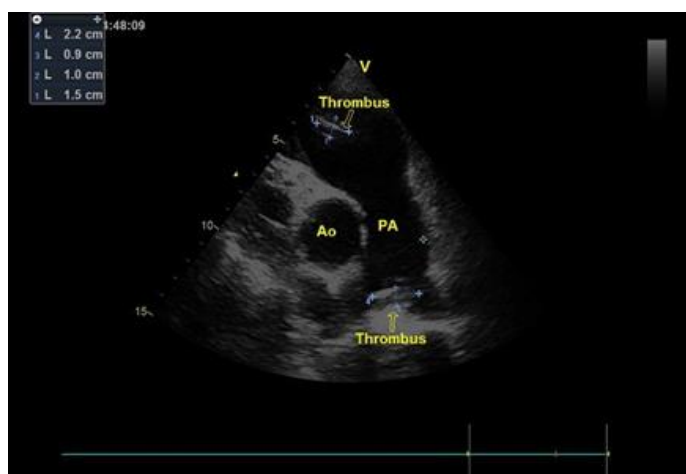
First patient, PSAX view on echocardiography showing the presence of a thrombus within the right ventricle measuring 15x10mm, another thrombus located at the bifurcation of the pulmonary artery measuring 22x9mm
